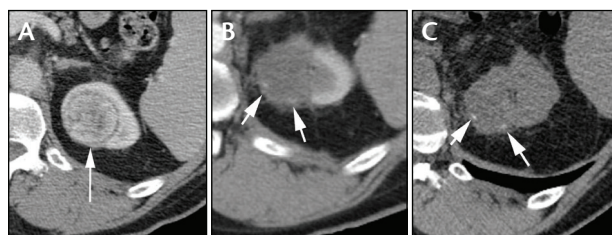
Contrast-enhanced CT demonstrated a solid right renal mass (A). One year after cryoablation, tumor recurrence was suggested by the interpreting radiologist (B, arrows); however, review of the corresponding noncontrast CT image (C) showed that the hyperdensity was due to dystrophic calcifications rather than enhancing tumor.
